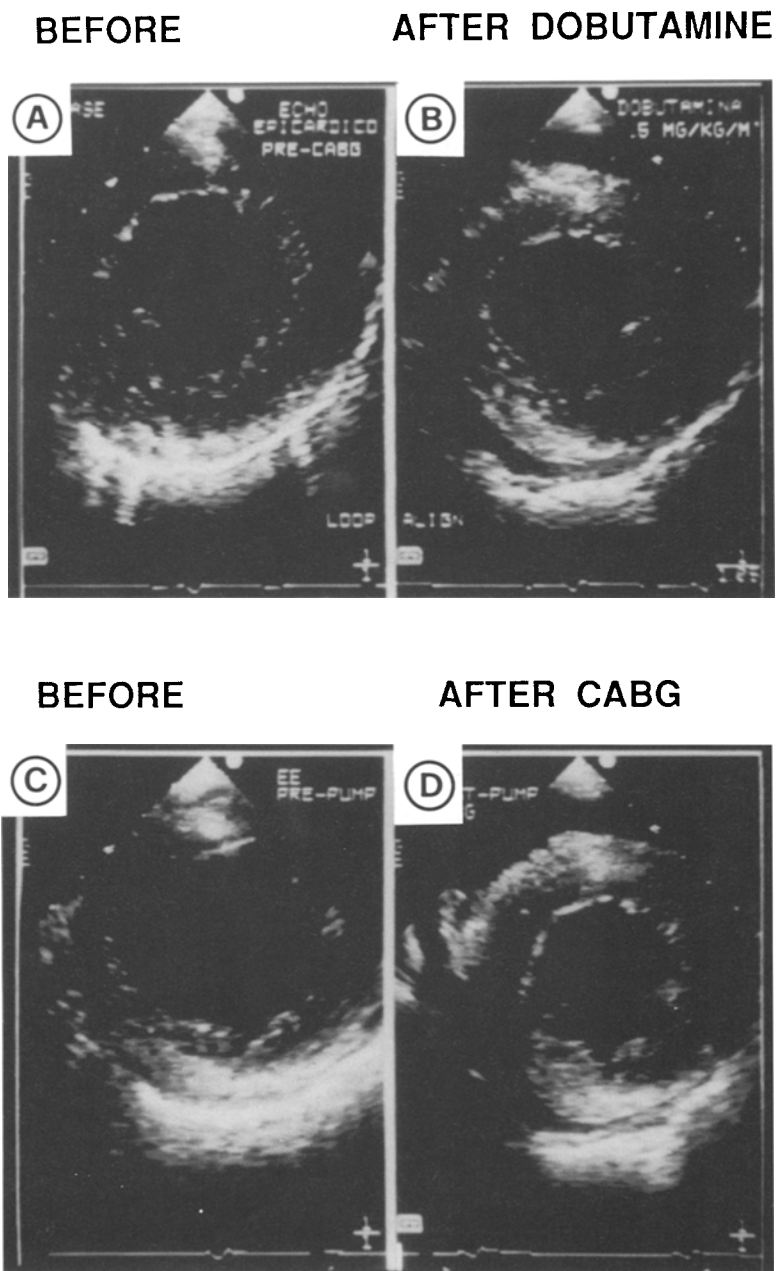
Intraoperative epicardial echocardiography end-systolic frames of a left ventricular short axis view before (A) and after (B) dobutamine infusion with clear improvement of the anterior and septal baseline akinesia. In C and D is shown a study of the same patient before (C) and immediately after (D) coronary artery bypass. The immediate improvement of the same segments is evident.
